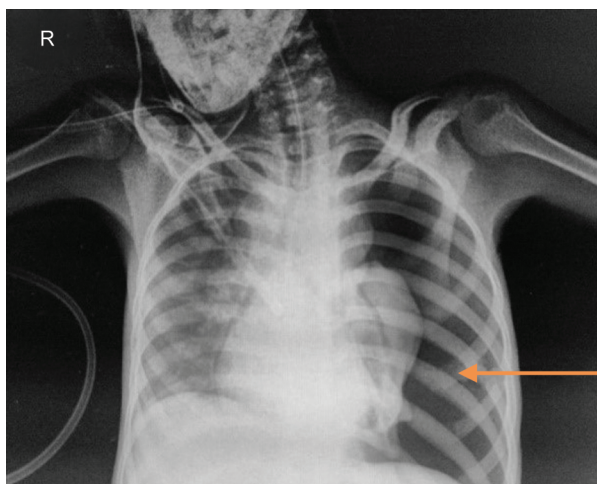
Chest X-ray showing pneumothorax on left side
